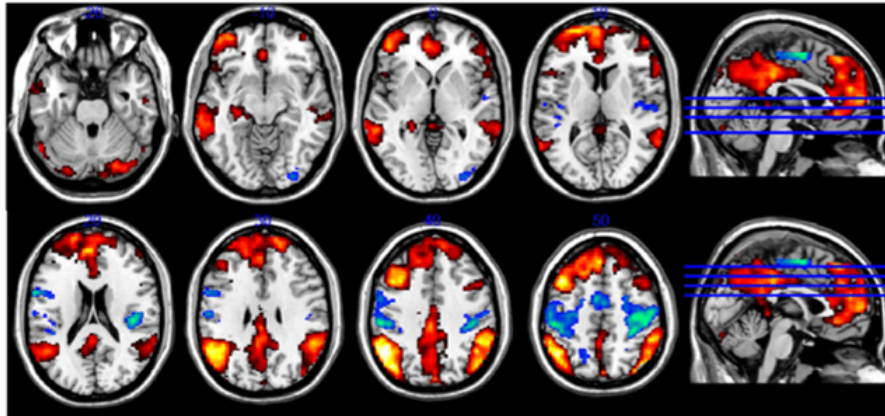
Functional magnetic resonance imaging (f-MRI) contrast.* [11]
